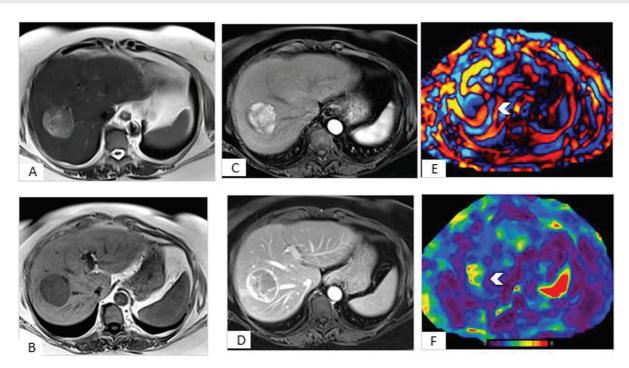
Hepatocellular carcinoma in a normal liver. (A) Axial T2 HASTE image shows intermediate signal intensity mass in right lobe with low signal intensity in T1W image (B). (C) Postcontrast late arterial phase image shows hyperenhancement, and portal phase (D) shows washout with capsular enhancement. (E) MRE wave map shows normal amplitude background waves with distortion at the level of the mass (arrowhead). (F) Stiffness map shows focally raised stiffness within the mass (arrowhead). HASTE, half-Fourier single-shot turbo spin echo; MRE, magnetic resonance elastography; T1W, T1-weighted.
